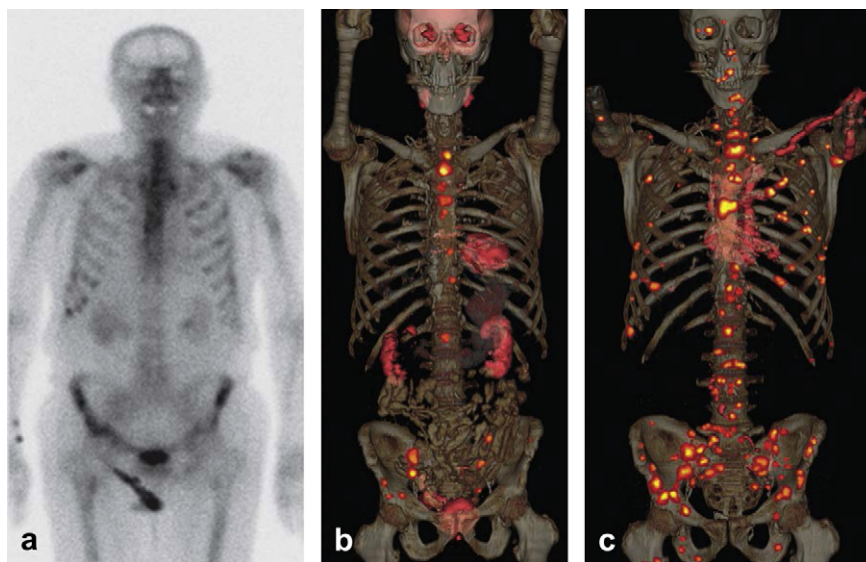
Images in 79-year-old man with castrate-resistant progressive metastatic prostate cancer (Gleason score, 9; prostate-specific antigen level, 91 ng/mL) who underwent (a) technetium-99m bone scanning, (b) FDG-PET/CT, and (c) FDHT-PET/CT within the same week. Note the markedly larger number of bone and lymph node metastases demonstrated on c as compared to b or a. Two months after imaging, bone biopsy from the left ilium (the site of suspicious bone metastases demonstrated only on c) showed metastatic disease from primary prostate adenocarcinoma. (Reprinted from Hricak H. *Oncologic imaging: a guiding hand of personalized cancer care*. *Radiology*. 2011 Jun; 259(3):633–640).
